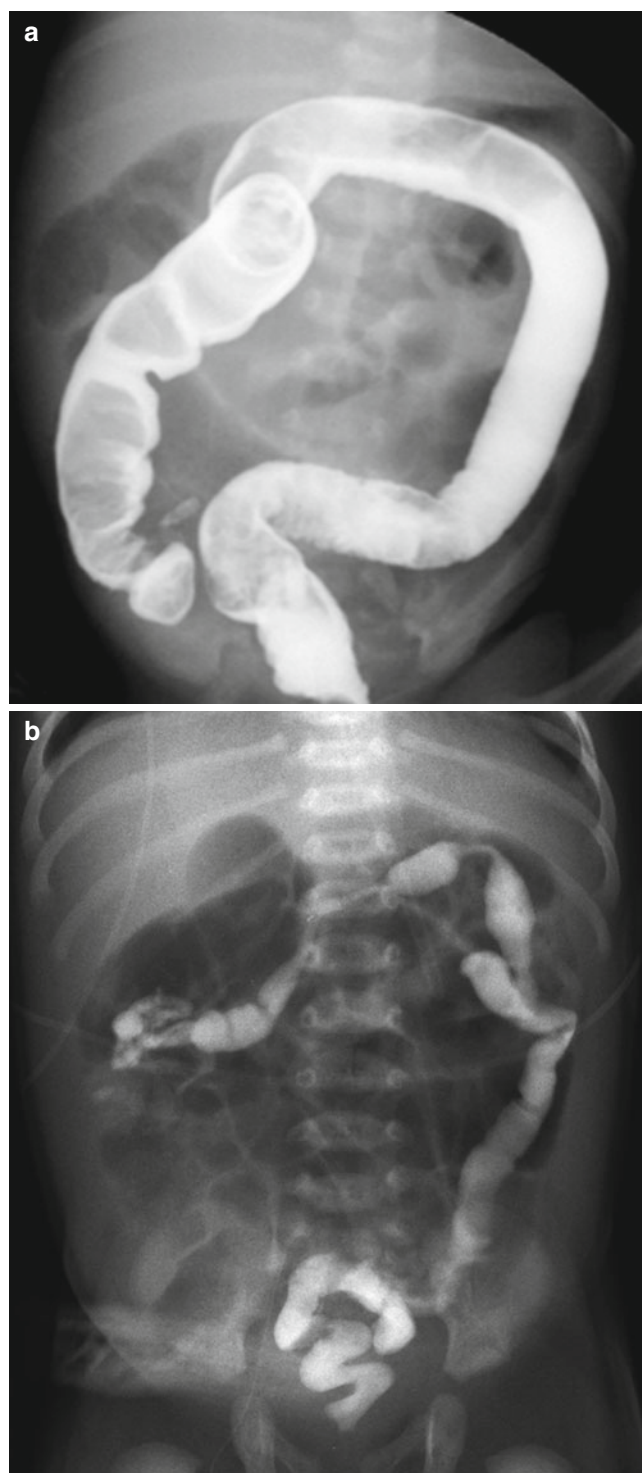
Total colonic aganglionosis in two infants. (a) Colon study in a 3-week-old infant who presented with abdominal distension and poor oral intake with a history of failure to pass meconium shows shortened colon with decreased redundancy, assuming the question mark appearance. Transition zone is not seen. The caliber of the entire colon is slightly decreased relative to small bowels, which show gaseous distension. (b) In another 3-day-old newborn with bilious vomiting, delayed radiograph after water-soluble contrast enema shows diffusely decreased caliber of the entire colon with contrast retention. Cecum is positioned high with shortening of the ascending colon. There is gaseous distension of small-bowel loops. Pathology confirmed aganglionosis involving not only colon but also ileum
